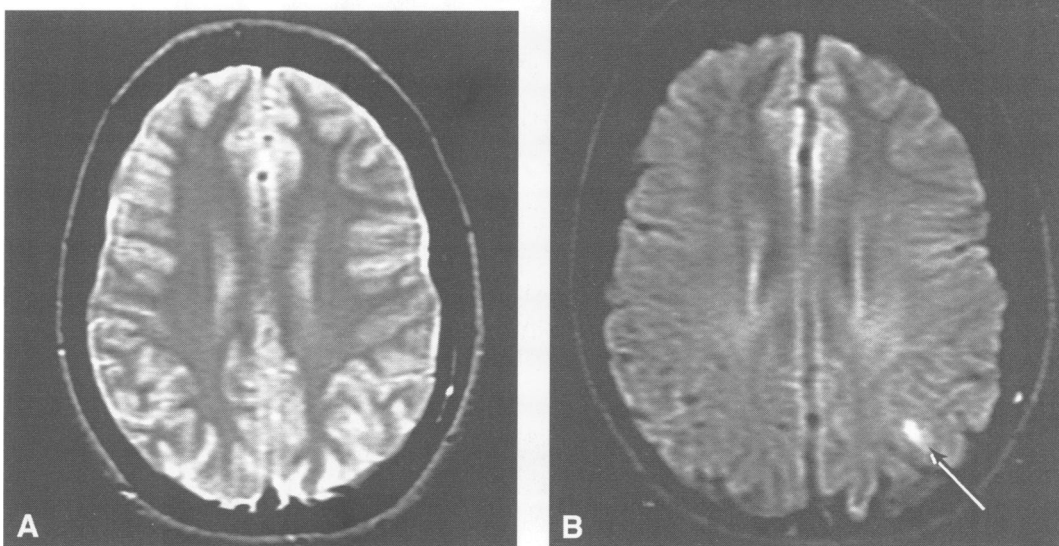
Case 9: transverse SE 2500/80 (A) and FLAIR 6000/160/2100 (B) images. A lesion is only seen in the left parietal region (B) (arrow).
